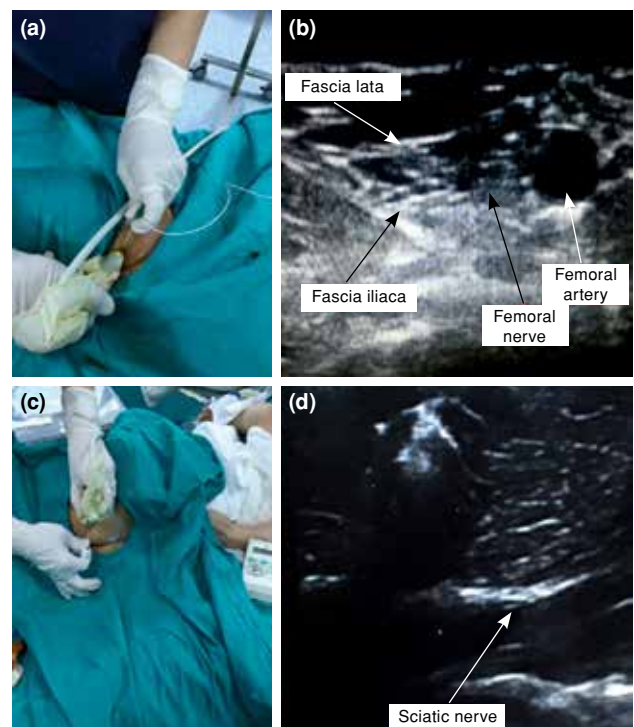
(a, b) Ultrasound-guided femoral nerve block. (c, d) Ultrasound-guided sciatic nerve block.
